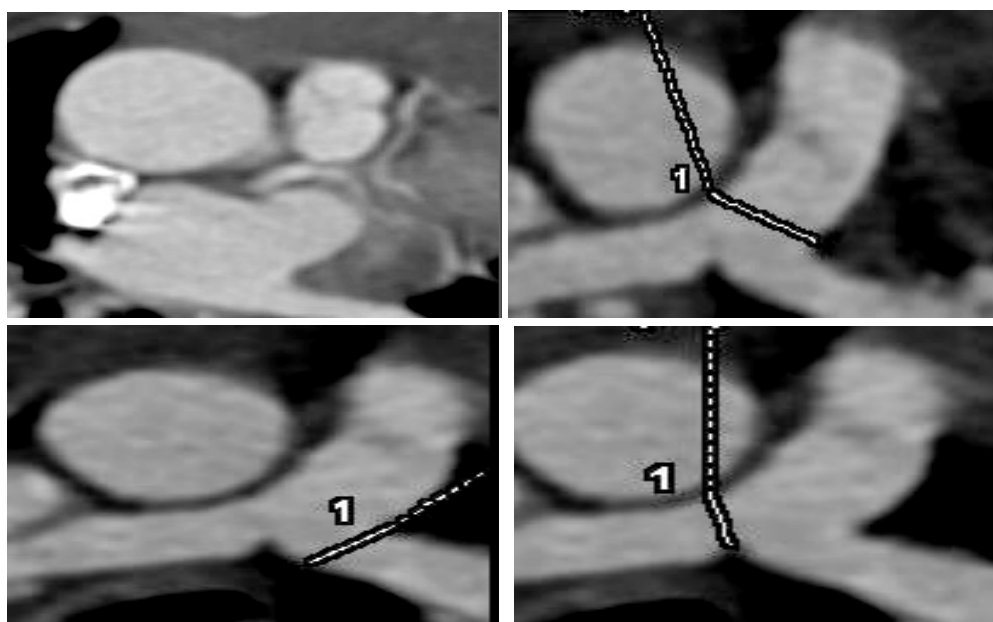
CTA images of pulmonary arteries & annulus. (a) oblique axial image of pulmonary annulus, (b) oblique axial image shows MPA measured before bifurcation, (c) Oblique axial image shows LPA measured in proximal part, (d) oblique axial image of RPA measured in proximal part. All the measurement shows as solid lines.
